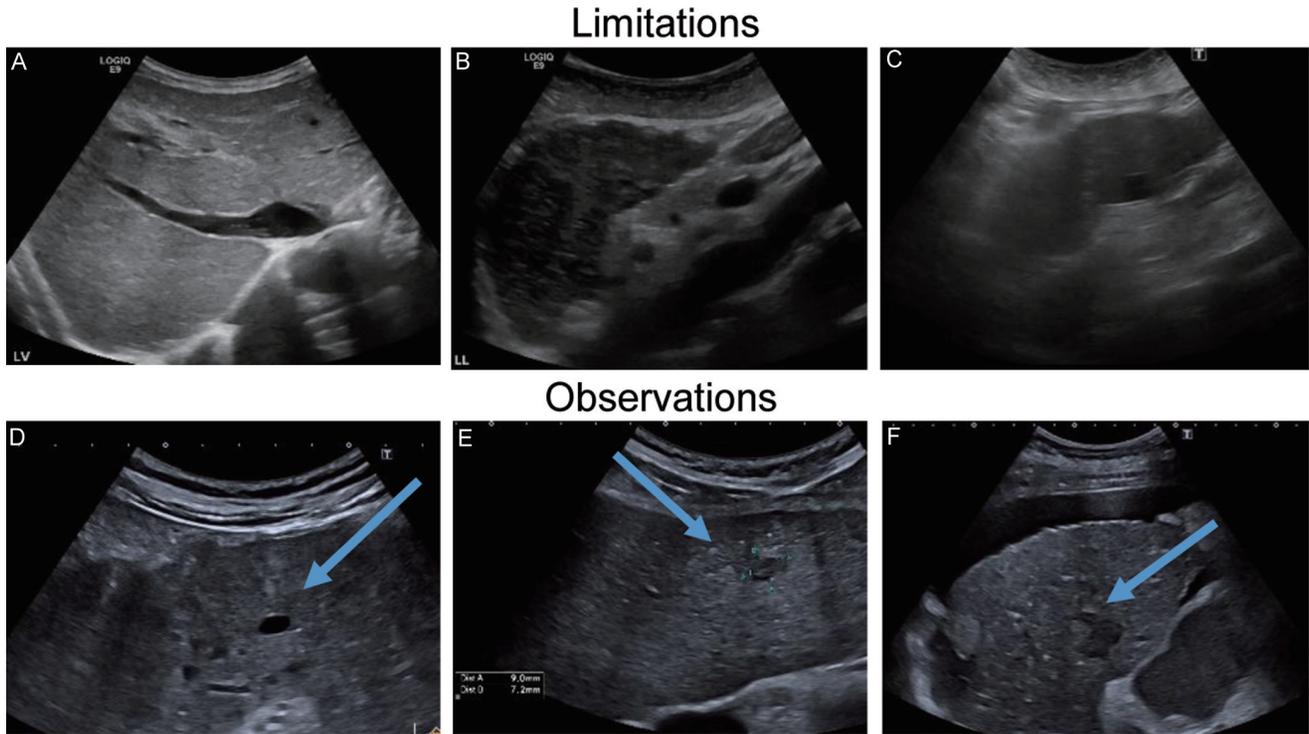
Scoring of visual limitations (upper panel, A–C) and observations (lower panel, D–F) in ultrasound, adapted by Fetzer *et al*.²⁶ (A) Visualization score A (minimal limitations, i.e. limitations if any are unlikely to meaningfully affect sensitivity). (B) Visualization score B (moderate limitations, i.e. limitations may obscure small masses). (C) Visualization score C (severe limitations, i.e. limitations significantly lower sensitivity for focal liver lesions). (D) Category negative (i.e. no observation or only definitely benign lesion). (E) category subthreshold (i.e. observation <10 mm in diameter, not definitely benign). (F) category positive (observation ≥10 mm in diameter, not definitely benign or new thrombus in vein).
